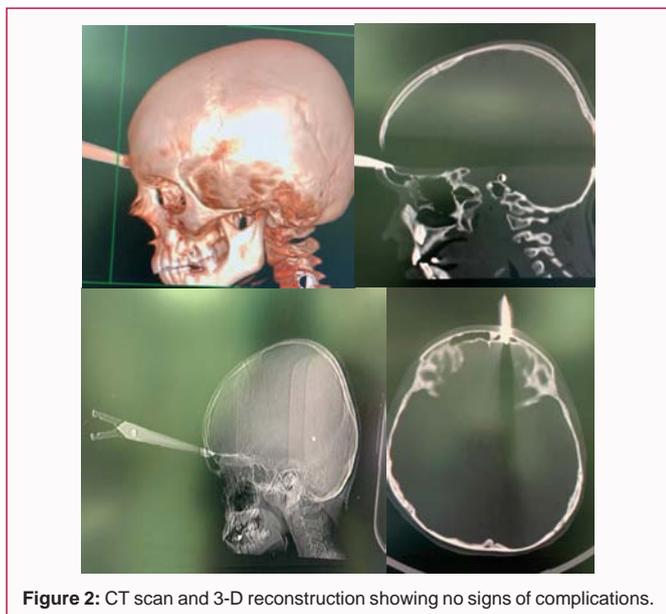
CT scan and 3-D reconstruction showing no signs of complications.
